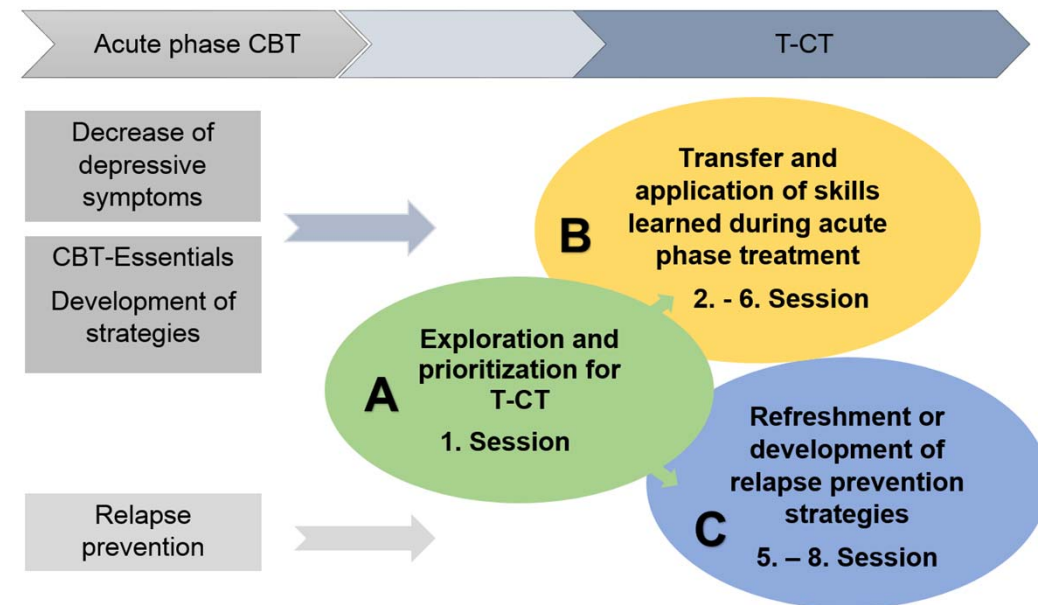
T-CT intervention scheme
